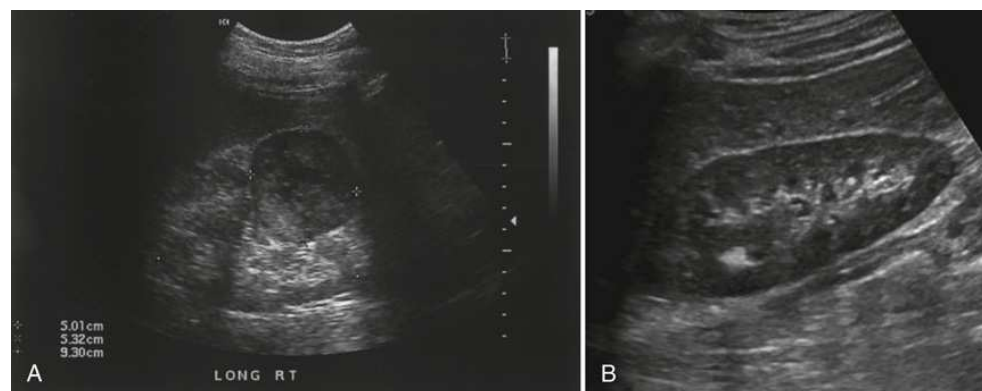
(A) Sagittal sonogram shows hypoechoic mass in anterior right kidney. (B) Sagittal sonogram of right kidney shows hyperechoic kidney stone. Courtesy of Susanna Ovel RT, RDMS, RVT.
